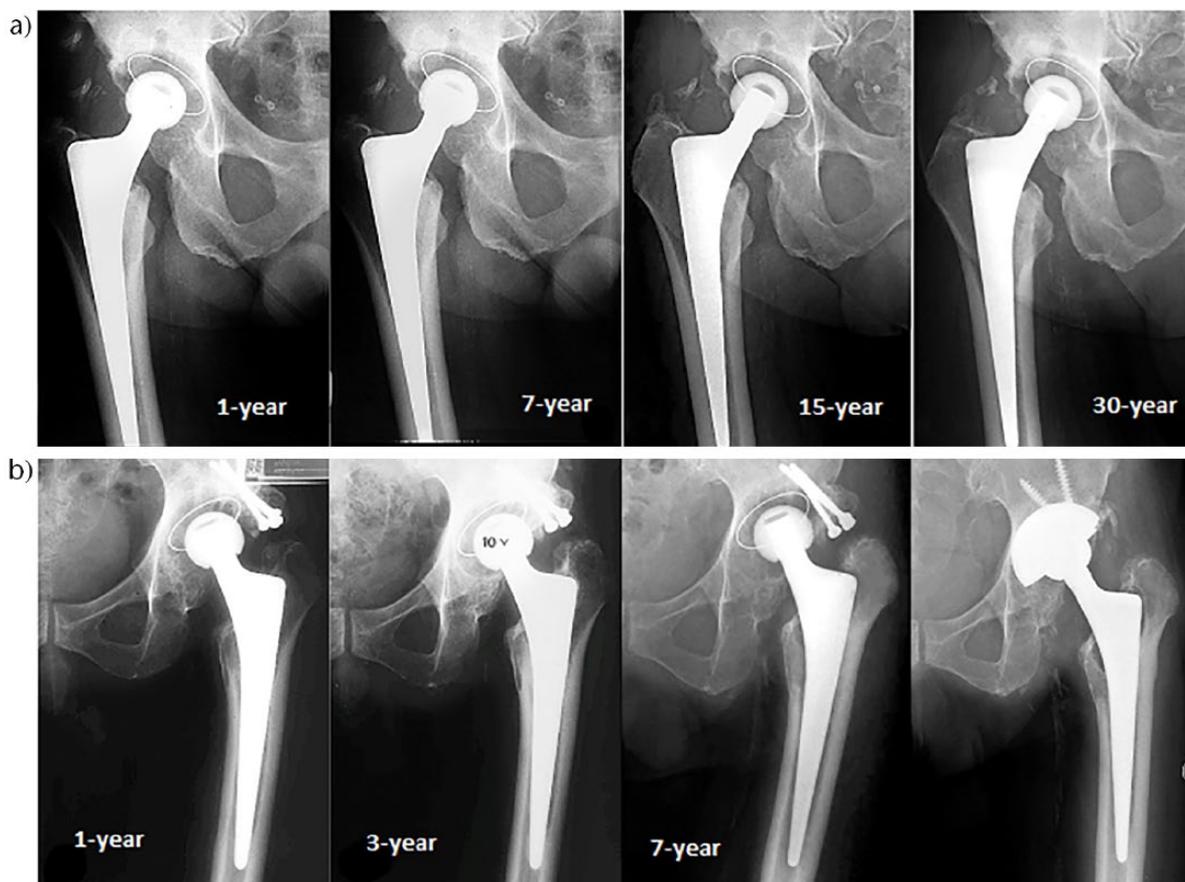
a) Successive AP radiographs of a CLS-Spotorno® stem at one-year, seven-year, 15-year and 30-year follow-up revealing no stress-shielding and distal cortical hypertrophy. b) Successive AP radiographs of a CLS-Spotorno® stem at one year, three years, seven years and after a revision surgery performed to change the worn polyethylene of the acetabular cup shows that wear-related osteolytic lesions are restricted to the proximal zones of the femur.
